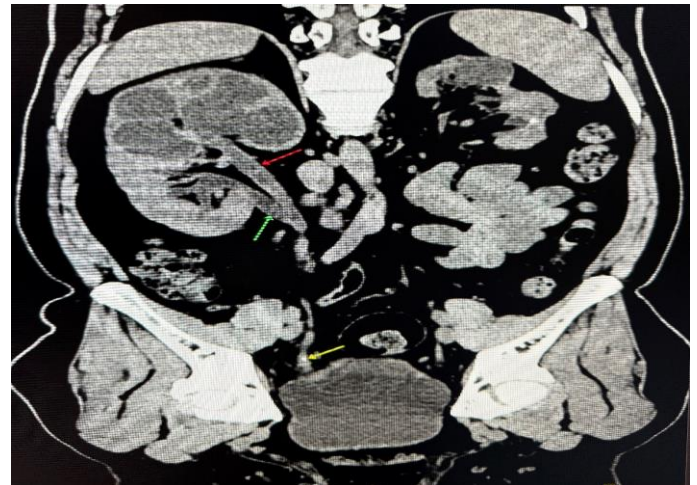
Sagittal cut of CT KUB Plain showing Right Duplex pelvicalyceal system with Duplex ureter (upper moiety (red arrow), lower moiety (green arrow) with moderate to severe dilatation of calyces and renal pelvis at upper moiety of right kidney. Well-defined ovoid hyperdense calculus of size measuring 3.1x2 mm noted at the distal end of upper moiety ureter causing retrograde hydroureter (yellow arrow).
